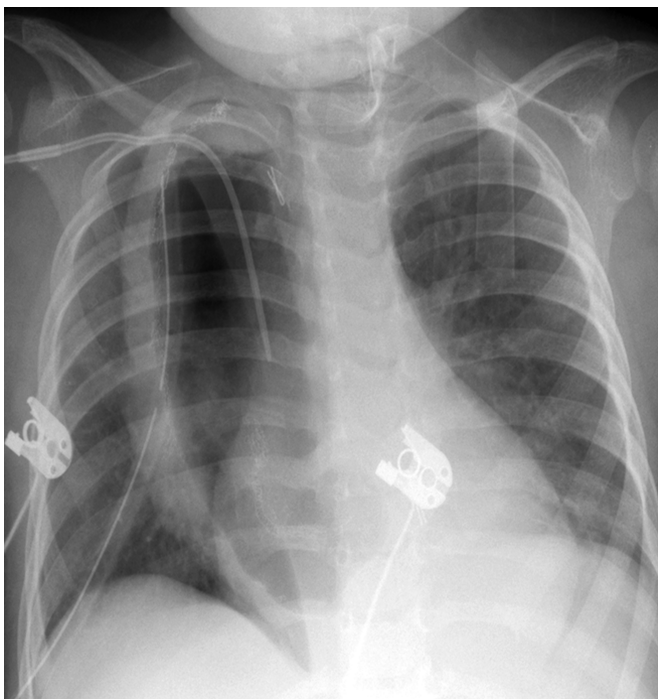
Postoperative chest radiograph after thoracoscopic-assisted esophagectomy and laparoscopic gastric pull-up demonstrates the gastric conduit occupying a large portion of the right hemithorax.
